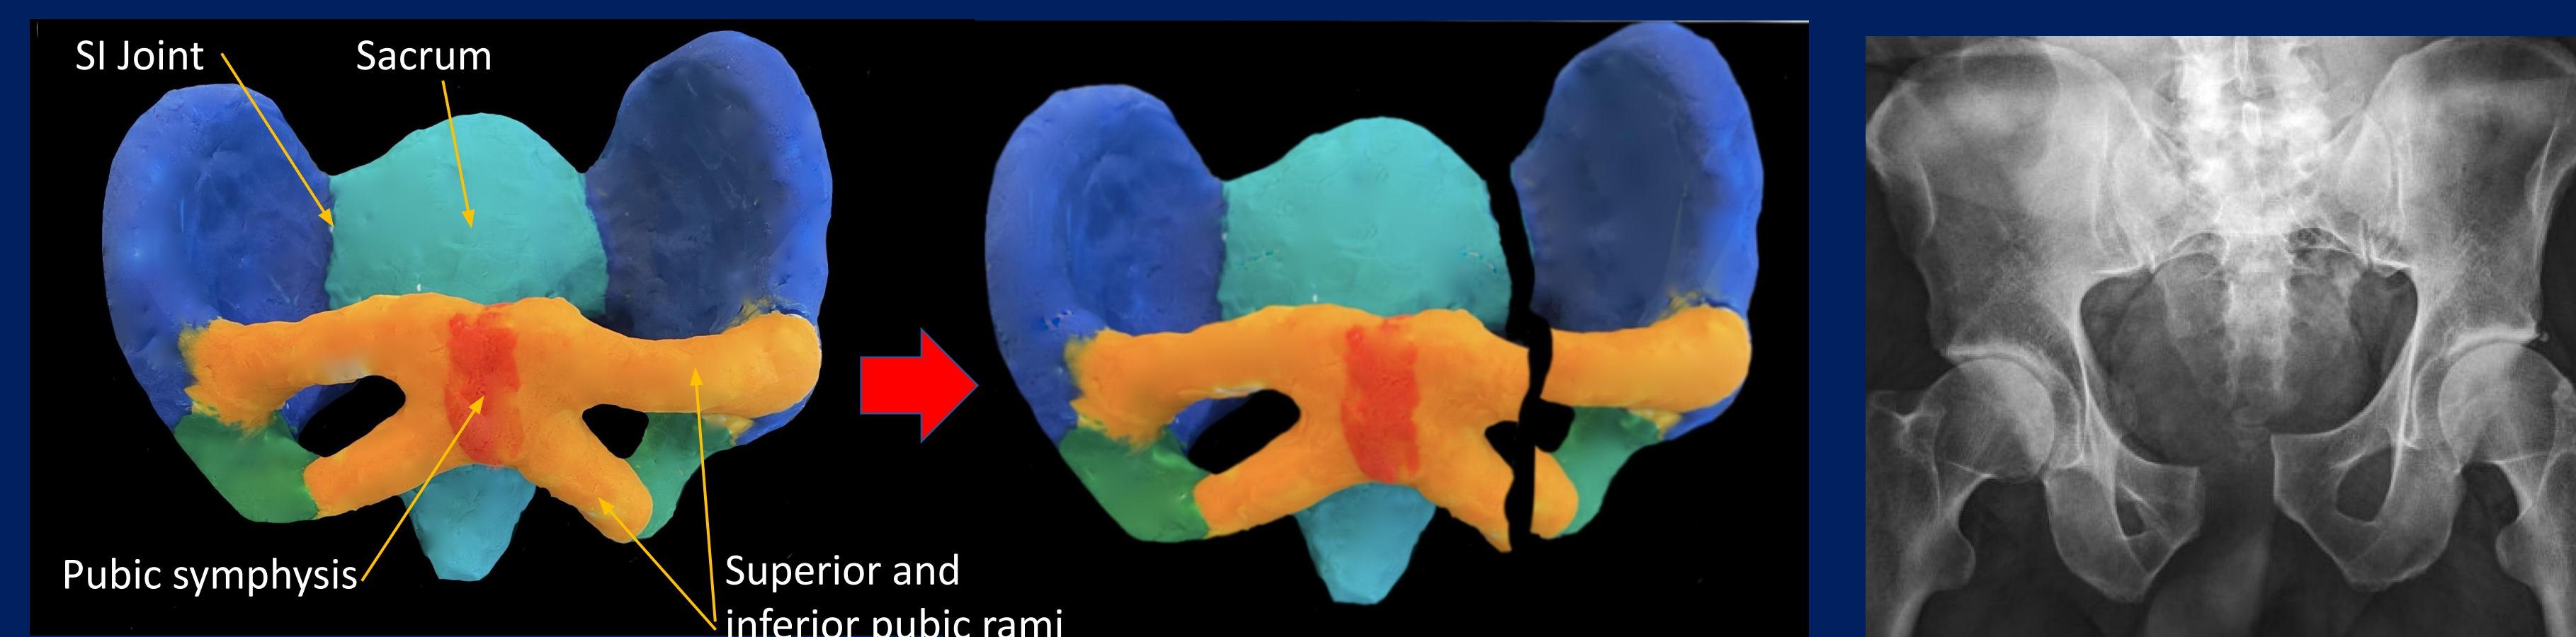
Clay model of a normal pelvis (left) and a model demonstrating a vertical shear injury (middle) with fracture through the left superior and inferior pubic rami (in orange) and SI joint injury. Pelvic AP radiograph (right) demonstrates vertical shear injury with pubic symphysis diastasis and left SI joint injury.
